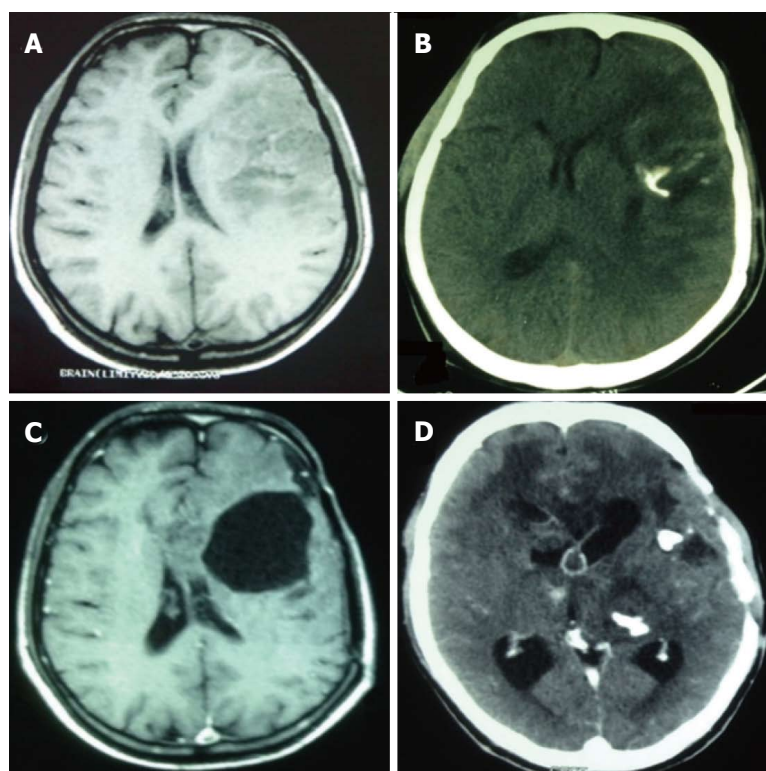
Radiological scans and findings before each surgical resection. A: MRI scans at initial diagnosis suggestive of glioma; B: CT scans at first recurrence showing calcification indicative of oligo-component presence; C: MRI scans just before third surgical intervention; D: CT scans before last resection confirming increased calcification. MRI: Magnetic resonance imaging; CT: Computed tomography.
